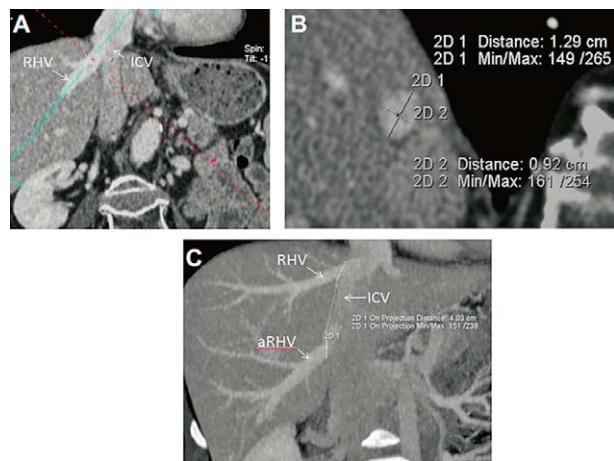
Computed tomography measurements of hepatic veins: (A) appropriate plane setting; (B) measurement of maximal and minimal diameter of hepatic vein in cross-section position; (C) measurement of RHV and aRHV confluences (University Medical Centre Ljubljana).
